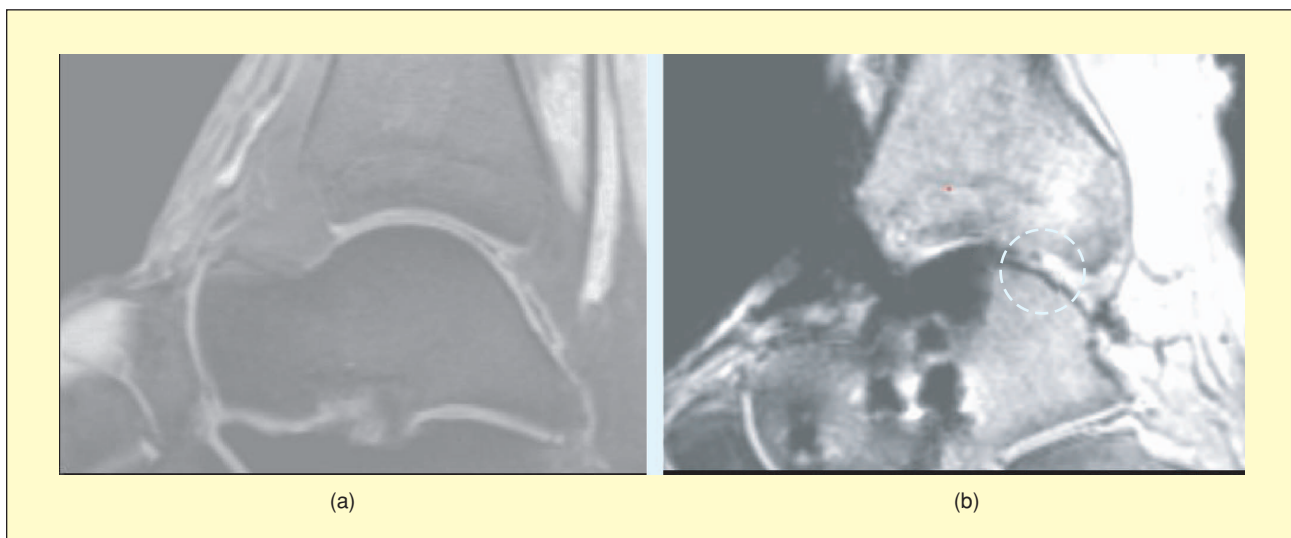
The medial view of the operative result in MRI: (a) the preoperative MRI overview and (b) the postoperative MRI with cartilage damage.
